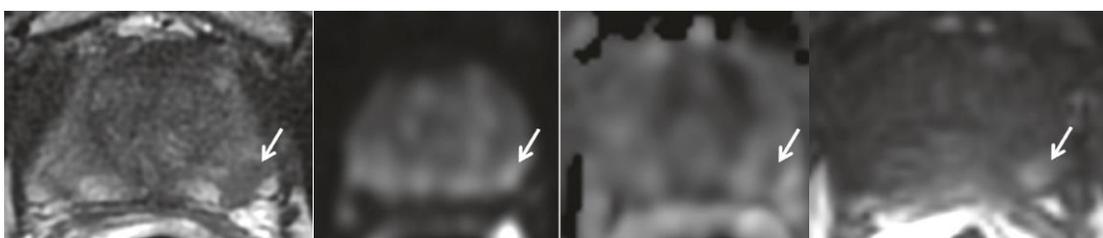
PI-RADS upgrading from 3 to 4 category in PZ. First, axial T2WI. Second, b1400 DWI. Third, ADC map. Fourth, DCE at 10 seconds. Shows a mildly focal high signal area on DWI and mildly hypointense on ADC (arrows), corresponding to a low signal intensity on T2WI (arrows). DCE shows early focal uptake at the same location (arrows), indicating positive contrast assessment. Obtained from (12).
